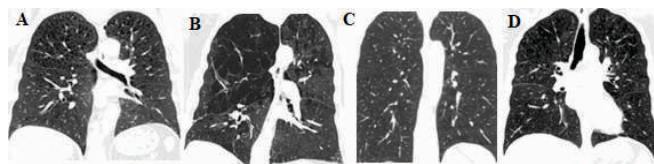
High resolution computed tomographic (HRCT) images Table 3 shows that the chronic pulmonary obstructive disease patients have low capacity of exercise in the above COPD patients have a test of 6 mint walk about the 78(65%) patients get tired during the walk text and 42(35%) were normal after the six min walk test. 95(79.2%) patients of the chronic obstructive pulmonary disease were obese, and 25(20.8%) were normal. Obesity was one of the major causes of the pulmonary restrictive disease.
